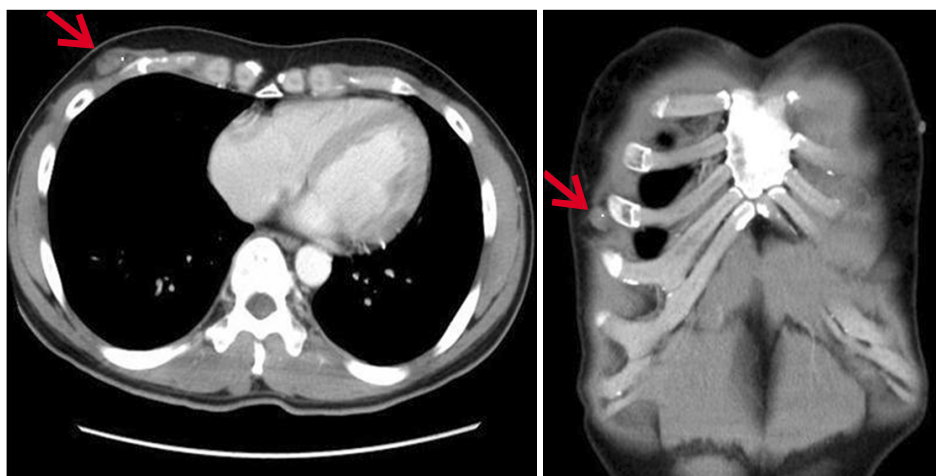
Chest CT scan showed that the heterogenous and well encapsulated soft tissue mass with fatty component and focal calcification.
